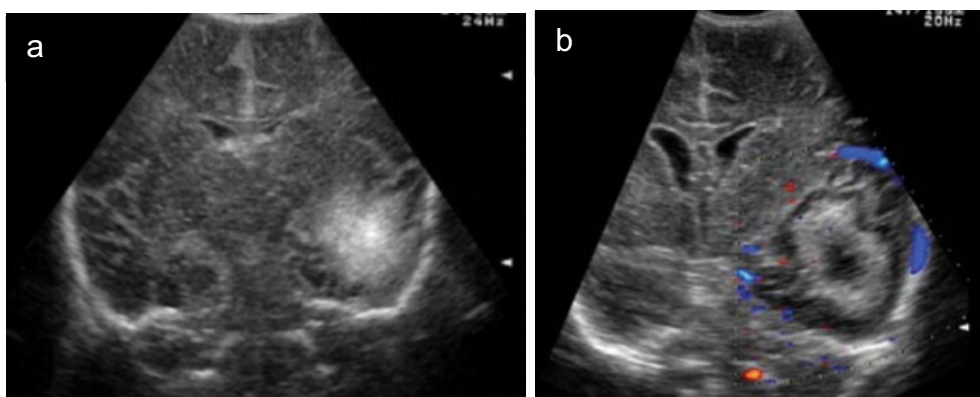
Coronal cranial ultrasound images showing an early abscess with hyperechoic area in left temporal lobe (a) and subsequent development of temporal abscess with hypoechoic centre and echogenic rim, absent Doppler flow within (b). (Ioana Alina Anca, 2009)
